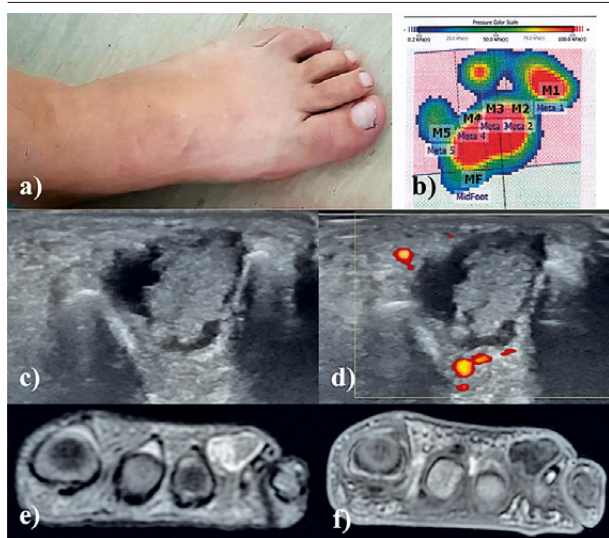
Female patient with IMB of the third intermetatarsal space having the following findings: a) clinical examination: opening toes sign of the third intermetatarsal space; b) baropodometry: increased plantar pressure at the same level; US: c) well-defined hypoechoic area within the intermetatarsal spaces, with anechoic areas inside, compressible and displaceable (fluid collection), d) without PD signal; MRI: e) well-defined mass in the intermetatarsal space with high signal intensity on coronal STIR sequences and f) peripheral enhancement on post-contrast coronal 3D T1 FSPGR.
